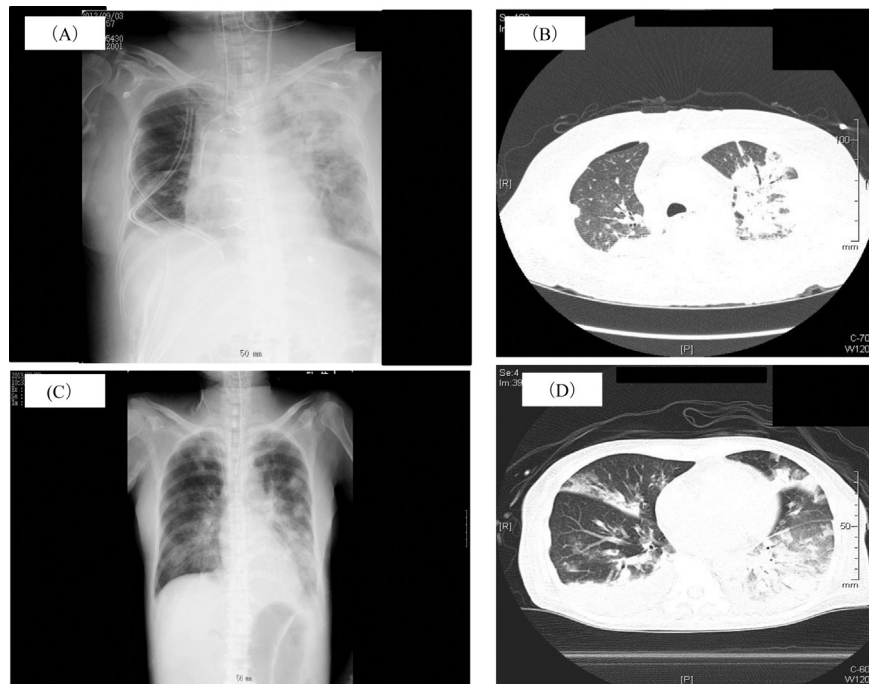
Chest radiography and computed tomography images of a 57-year-old patient with HAP and a 67-year-old patient with HCAP. Chest radiography (A) and computed tomography (B) images of 57-year-old patient with HAP show infiltration shadow mainly in left upper lung field. Those (C and D) of 67-year-old with HCAP show infiltration shadow mainly in left lower lung field.
